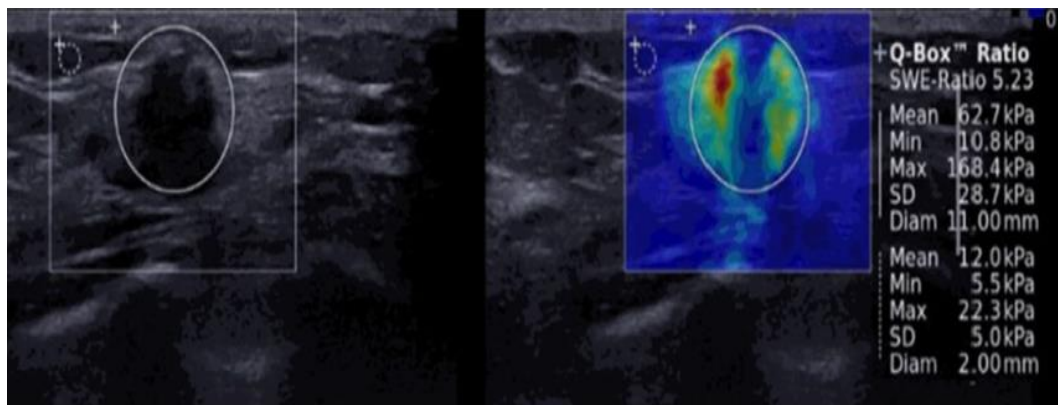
Ultrasound image on the left (B-Mode). Heterogeneous elasticity is represented by the irregular red mass in the shear-wave elastography image on the right. Calculations are made to determine the statistical parameters of ROI, such as mean, maximum, and minimum (Youk et al. 2017).
